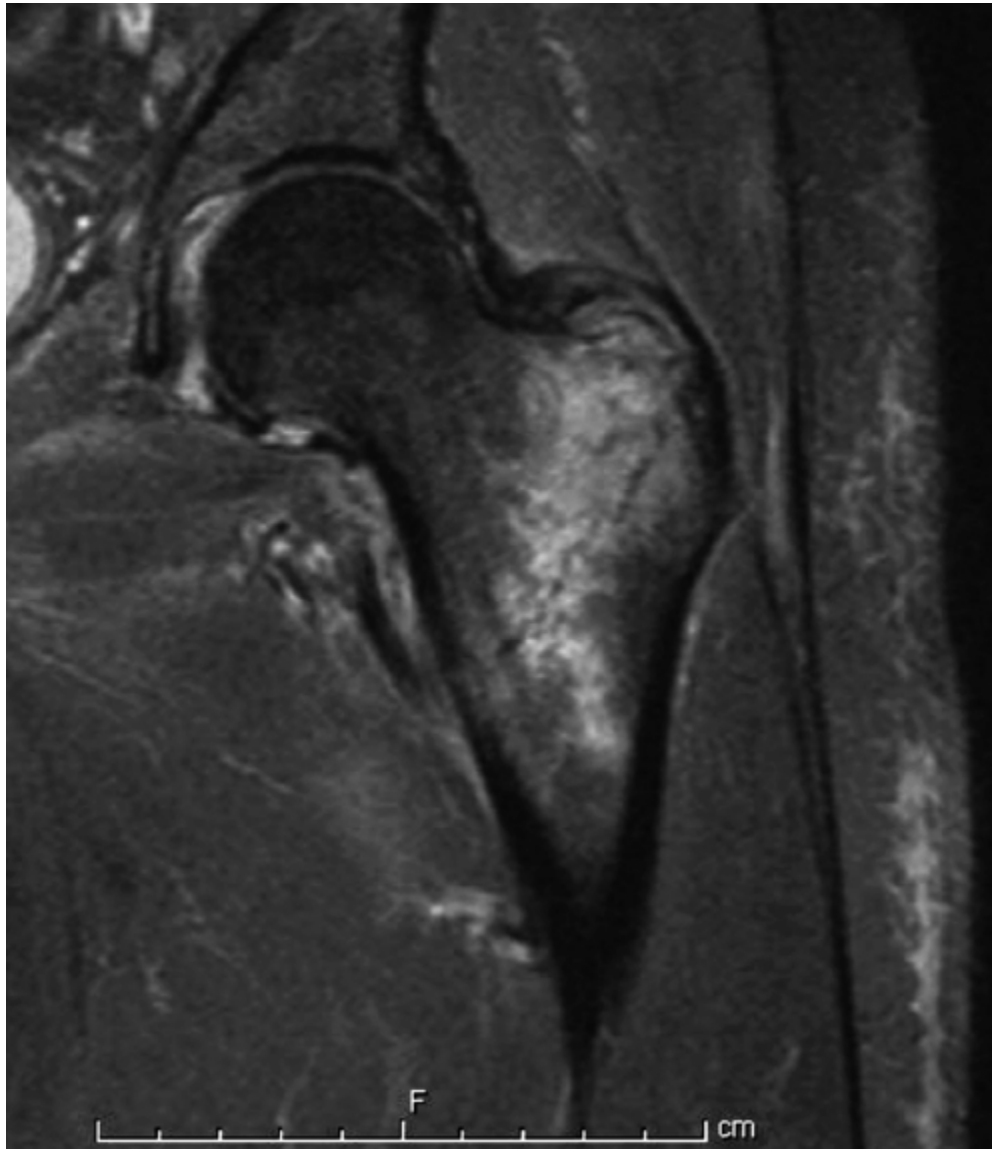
MRI revealing an occult intertrochanteric fracture.
